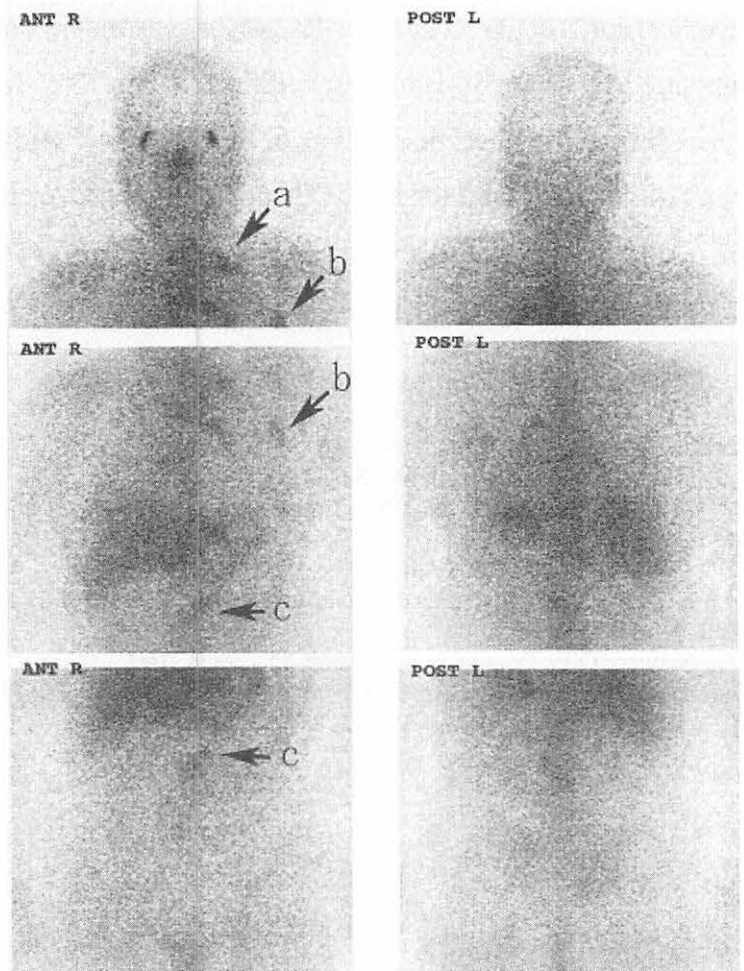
Gallium scintigraphy shows abnormal accumulations in the left cervix (arrow (a)), left axillary (arrow (b)), and the center of the abdomen (arrow (c)).
